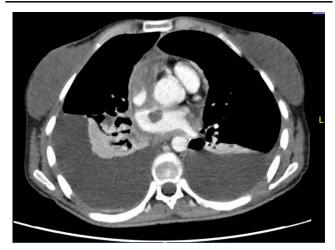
Computed tomography scan with contrast showing decrease in size of bilateral pleural effusion and a left atrial thrombus.
